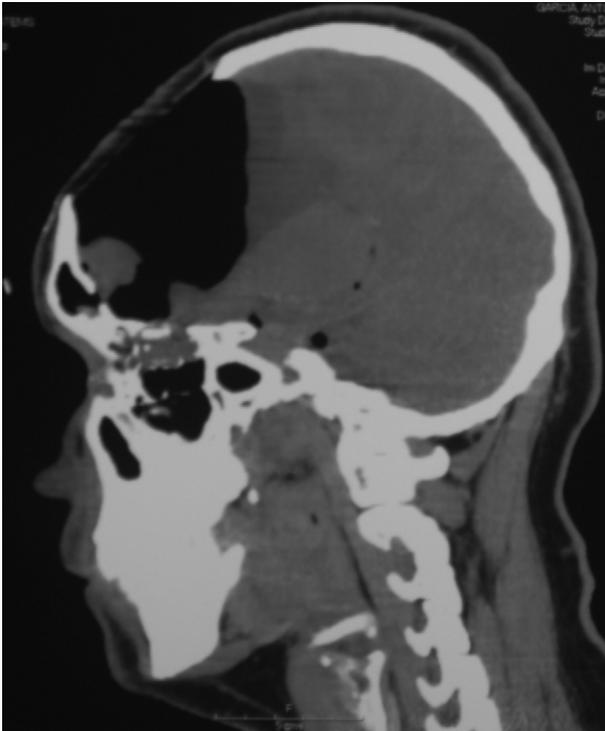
Preoperative computed tomogram showing a comminuted skull base and a large defect in the brain with retraction of the remaining brain parenchyma because of an ongoing massive cerebrospinal fluid leak.
